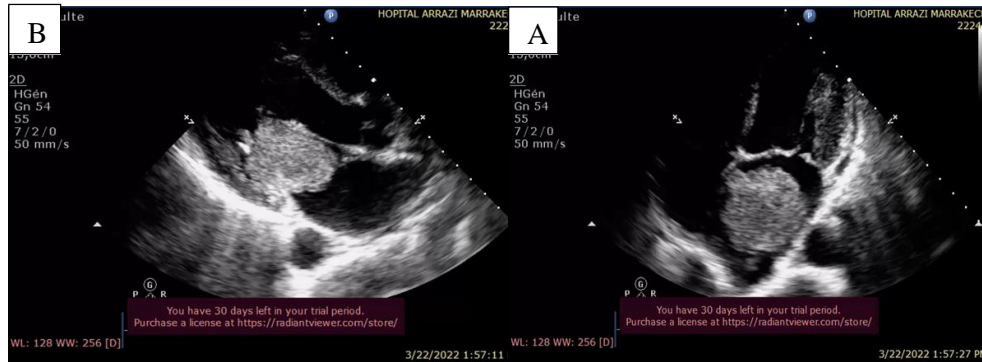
Echocardiography: mass with pedicle, of heterogeneous density and joined to the interatrial septum (A). The mass is adhering to the interatrial septum and has prolapsed through the mitral valve (B).
